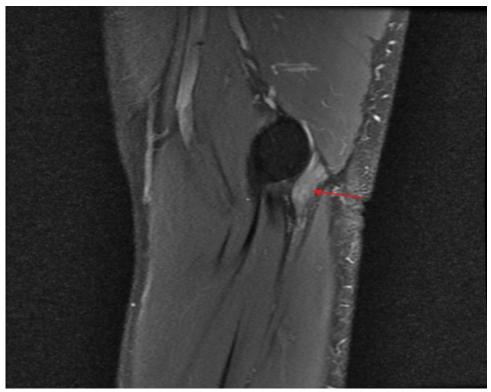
Sagittal PD MRI view demonstrate high signal intensity within the nerve
